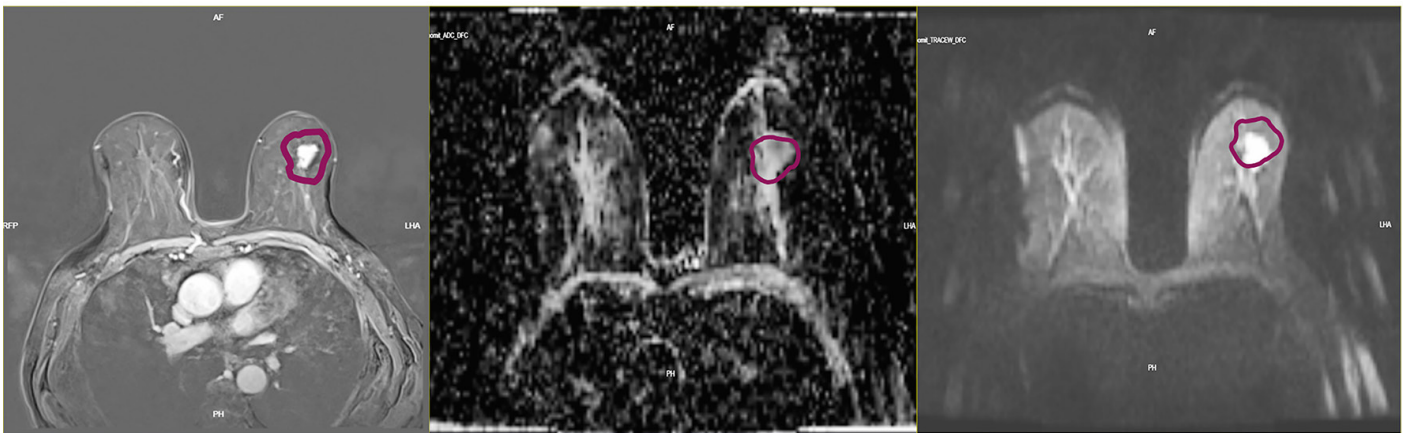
Breast magnetic resonance images demon strates an irregular mass, hyperintense on T2-weighted with homogeneous progressive enhancement on post contrast images and diffusion restriction on diffusion weighted imaging
